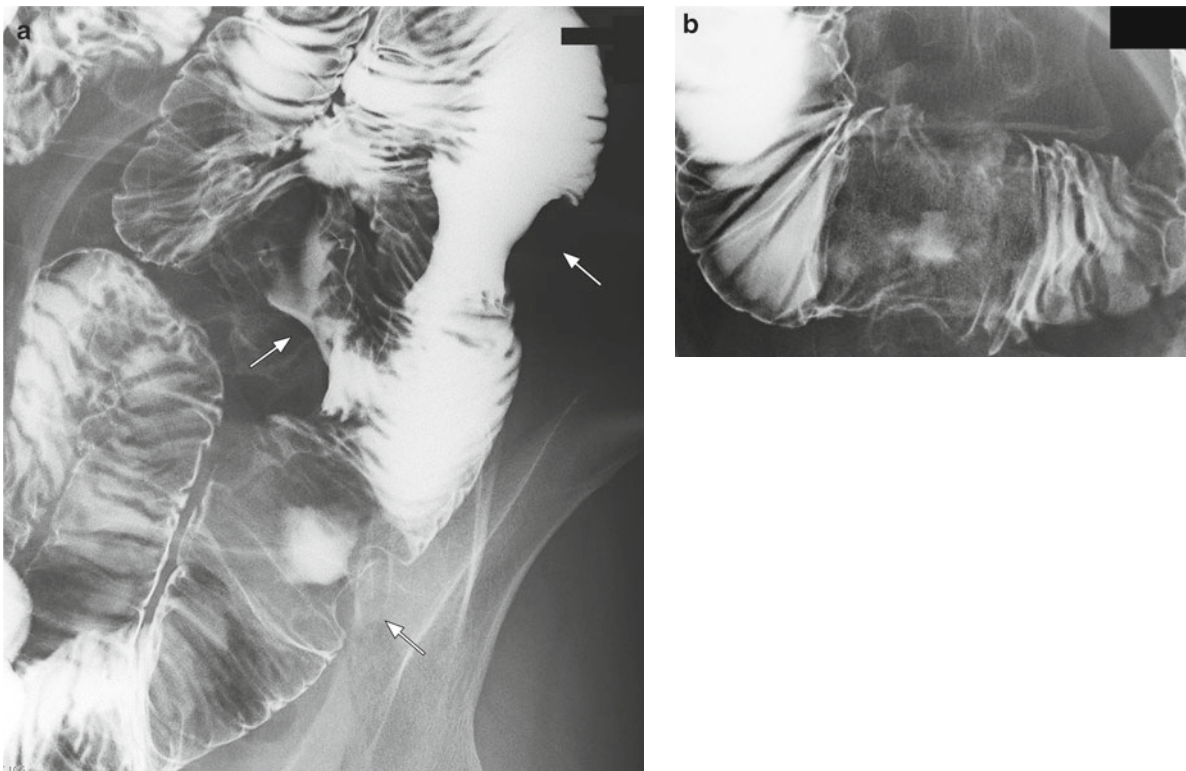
(a, b) Radiography showed multiple protrusions and ulcerative lesions in the duodenum (*right*) and jejunum (*left*)
